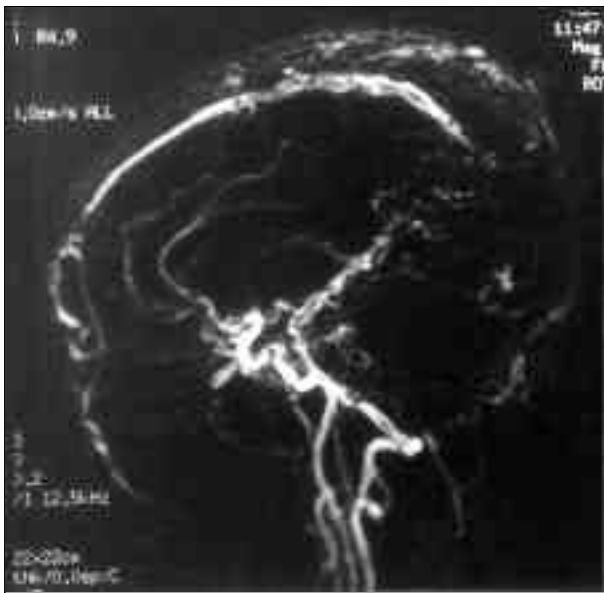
Left: T1-weighted sagittal MRI demonstrating a hyperdense thrombus (asterisk) completely filling the posterior part of the superior sagittal sinus (SSS). Right: Sagittal MRA shows the presence of a "parasagittal block" (asterisk) of an intracranial venous blood flow in the occipital region.
